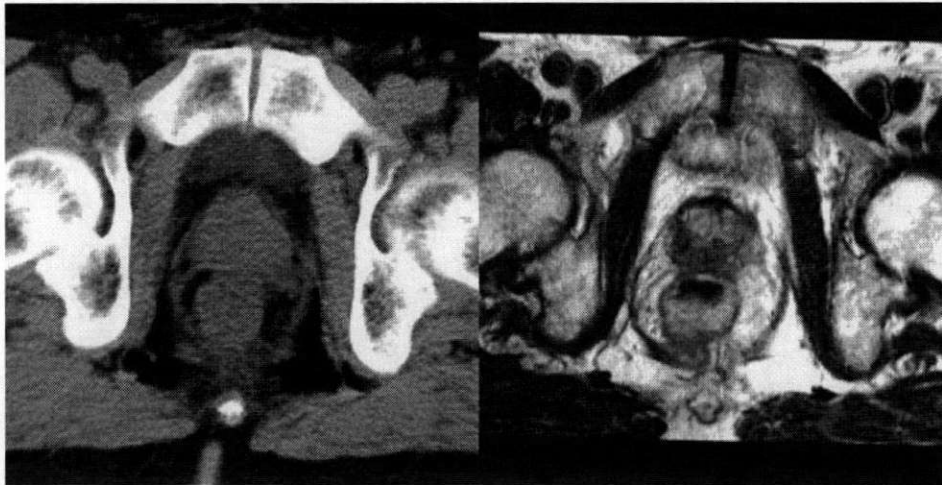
Computed tomography (left) and magnetic resonance (right) pelvic images used for planning prostate radiotherapy. The superior soft-tissue contrast of magnetic resonance is evident.
